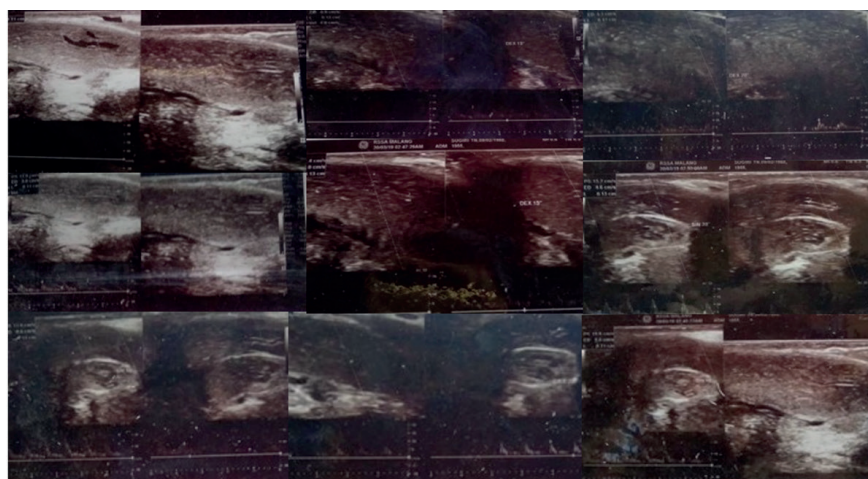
Penile USG Doppler found arterial insufficiency
